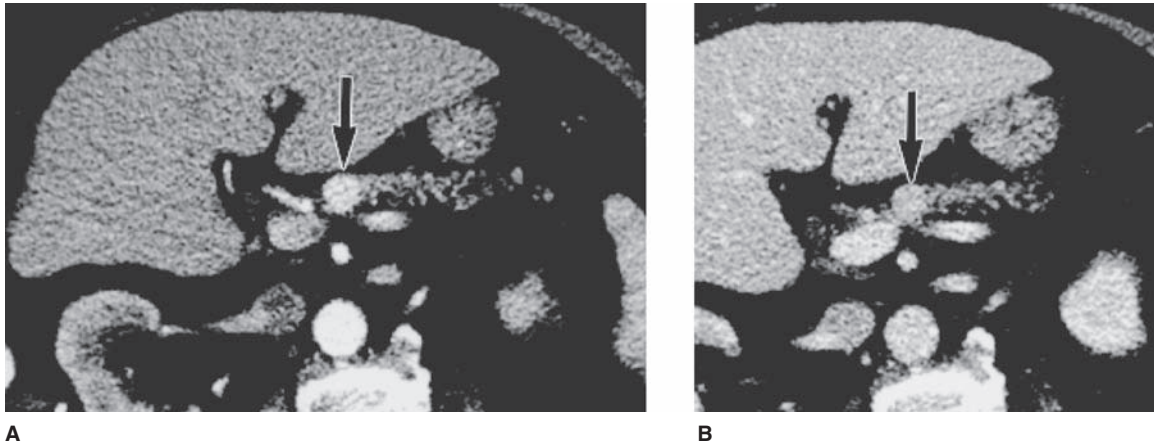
An 83-year-old man with life-threatening hypoglycemia and 1.2-cm insulinoma. The patient underwent distal pancreatectomy because enucleation was not possible as a result of lack of sufficient bridging pancreatic tissue. A. Axial CT image of pancreas obtained in arterial phase of enhancement shows small homogenous hyperattenuating mass (*arrow*) in neck of pancreas. B. Axial CT image obtained at the same level as A in venous phase of enhancement shows mass (*arrow*) to be less conspicuous than in arterial phase. (From Sheth S, Hruban RK, Fishman EK. Helical CT of islet cell tumors of the pancreas: typical and atypical manifestations. *AJR Am J Roentgenol.* 2002 Sep;179(3):726, with permission from the American Journal of Roentgenology.)
